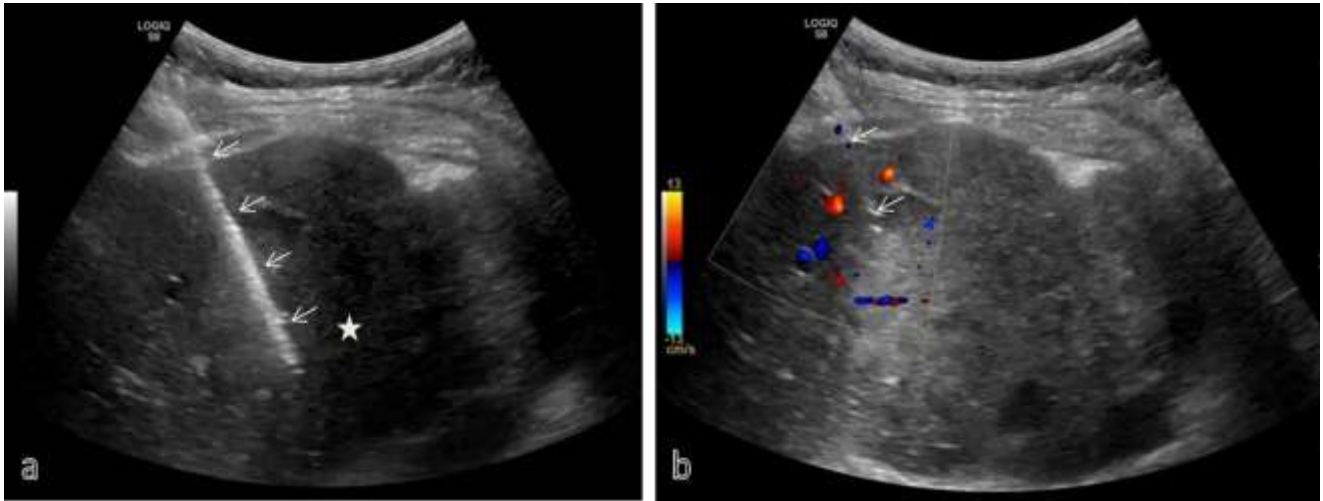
USG guided biopsy has been performed from the right lobe liver lesion in this suspected case of carcinoma gall bladder with liver metastasis. Almost entire needle (arrows) is seen in a with its tip in liver lesion (asterisk). Color doppler image shows vessels (in red and blue colors) on either sides of needle (arrow) which is carefully inserted avoiding the vessels.
